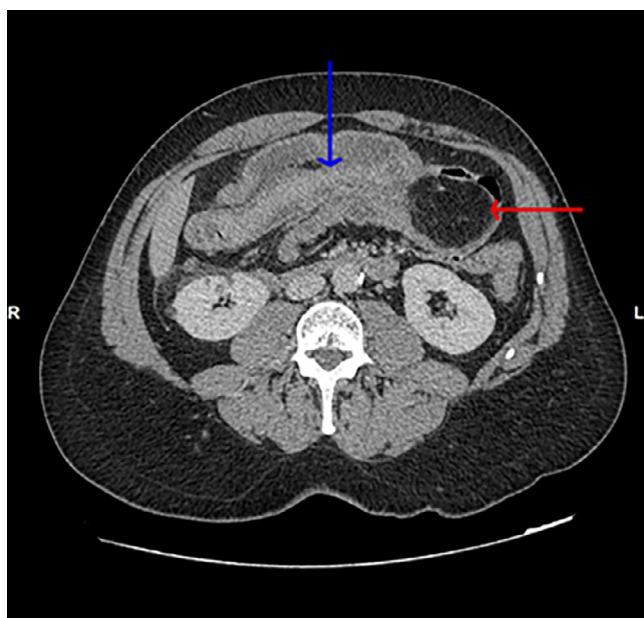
Axial cut of the abdominal CT scan showing the sausage-shaped appearance of intussusception (blue arrow), and the enclosed lipoma (red arrow).
